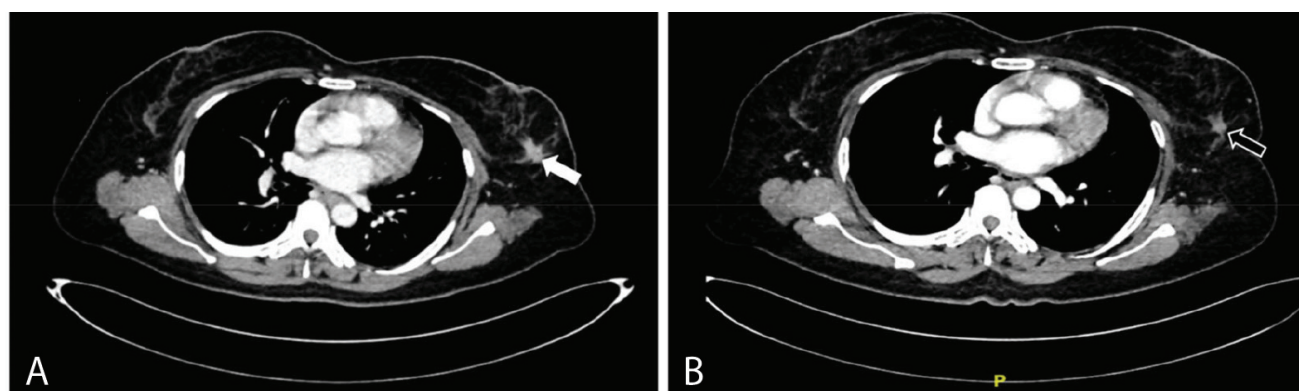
This figure shows: (A) Axial computed tomography of thorax with contrast demonstrating a 2.3×1.8 cm enhancing spiculated lesion (white arrow) in the upper outer quadrant of the left breast prior to treatment on image. (B) 3 years after completing the treatment, the similar lesion appears to be smaller in size measuring 1.2×0.9 cm on image.
